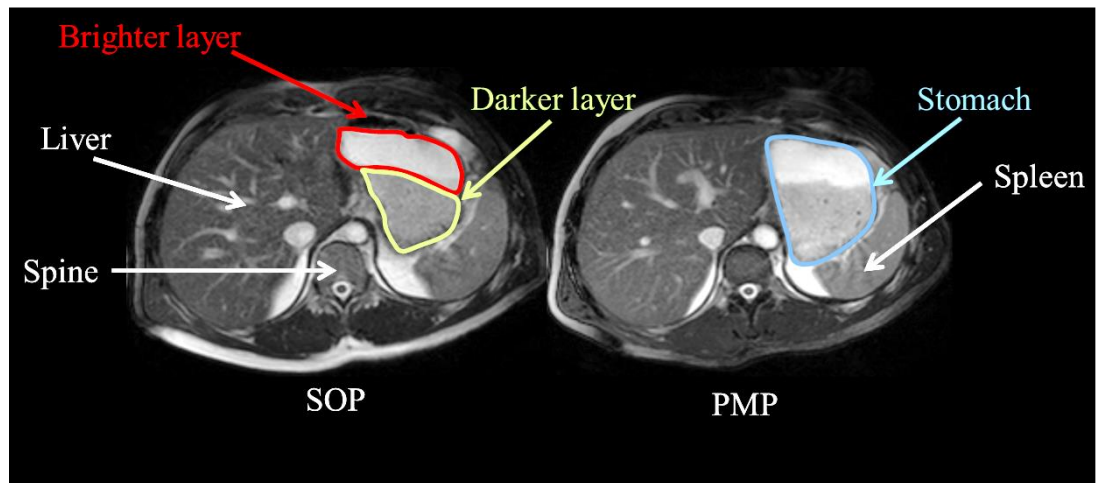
Representative example of axial MRI images through the same location in the abdomen of a healthy participant who consumed Scottish oats porridge (SOP) or pearl millet porridge (PMP) test meals on two different occasions. Images were taken at $t = 15$ min after feeding. Anatomical landmarks such as the liver, spine and spleen are indicated by the white arrows, whereas the stomach is circled in blue on the panel on the right. Both porridges showed clear layering (phase separation), with a darker layer at the bottom of the stomach (circled in yellow on the panel on the left) and a brighter layer at the top of the stomach (circled in red on the panel on the left).
